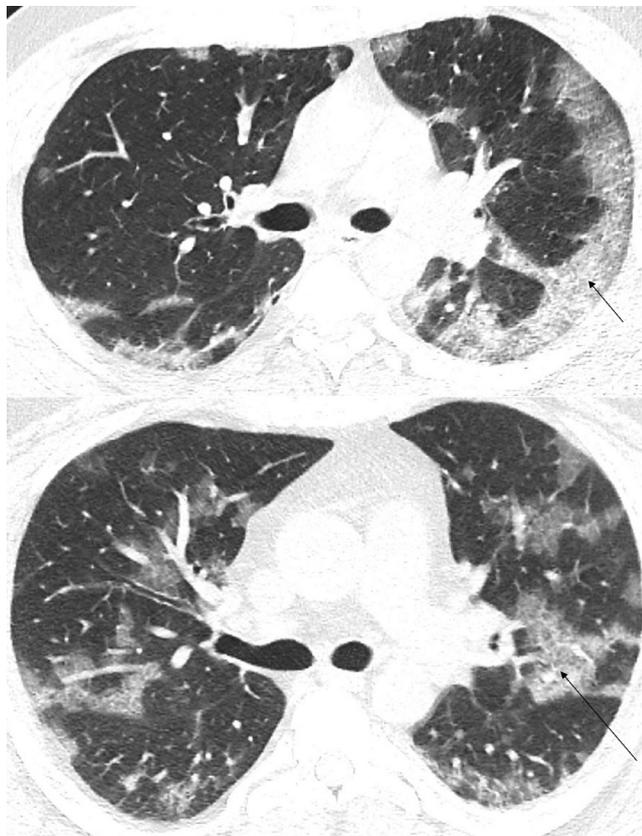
Chest CT. Crazy-paving appearance (arrows) in a patient with confirmed COVID-19
